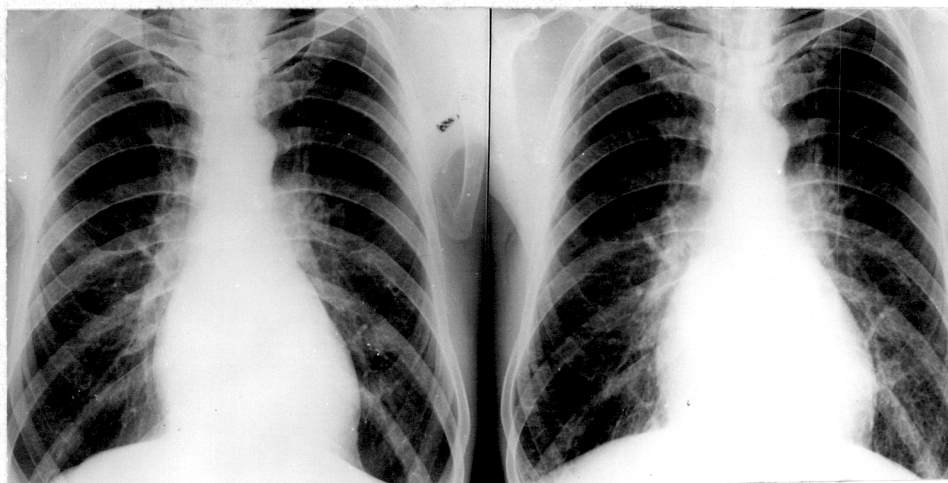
Chest radiograph of Patient number 41 in atrial fibrillation on the left, and one day after the establishment of sinus rhythm on the right. In sinus rhythm the heart is larger, pulmonary oedema is shown and Kerley's lines are present.
